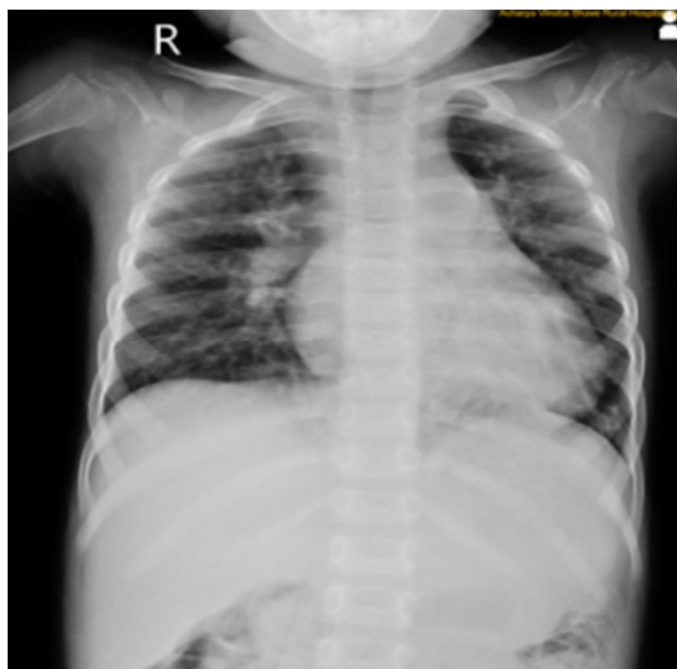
Shows the preoperative x-ray of the patient
